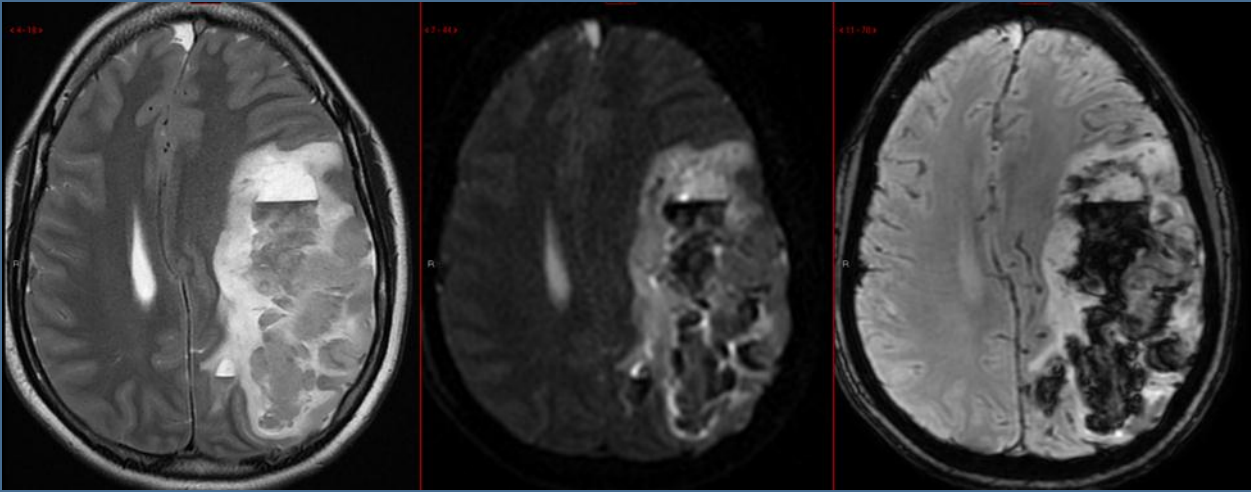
Axial T2W (right), DWI (center) and SWI (left) showing extensive confluent hemorrhagic infarct of the left cerebral hemisphere.
